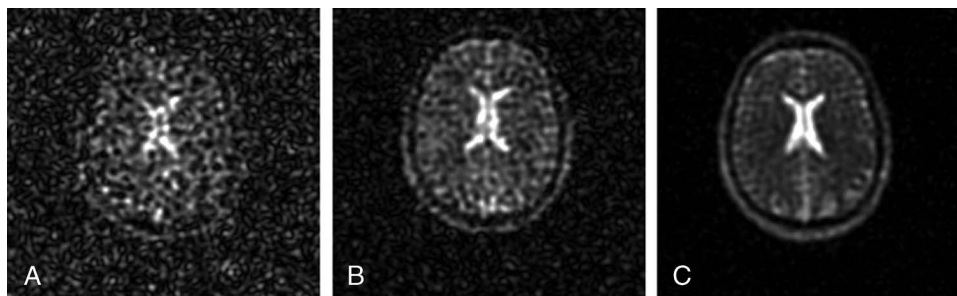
Sodium (^{23}Na) MRI at 1.5 (A), 3 (B), and 7 T (C). Images show that the SNR increases markedly with B_0 . Sequence parameters: TE (1.5 and 3 T), 0.2 milliseconds; TE (7 T), 0.5 milliseconds; TR, 50 milliseconds; flip angle α , 77 degrees; nominal spatial resolution, 4 mm³; acquisition time, 10 minutes 50 seconds. Reused with permission from John Wiley & Sons, Kraff et al.³⁶
